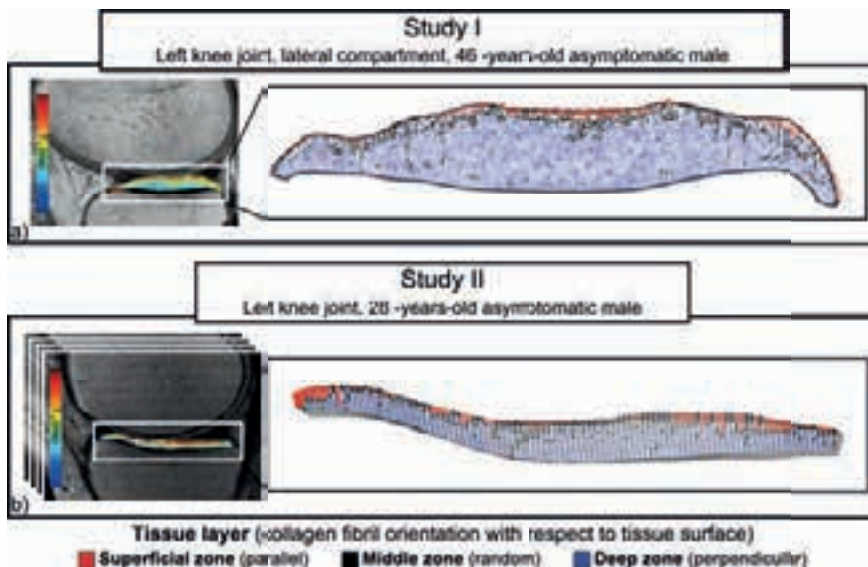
a) The subject-specific collagen fibril orientations in the tibial cartilage determined using  $T_2$  mapped MRI in study I. b) Subject-specific collagen fibril orientations at the location of the submodel in the tibial cartilage, determined from  $T_2$  MRI II.
